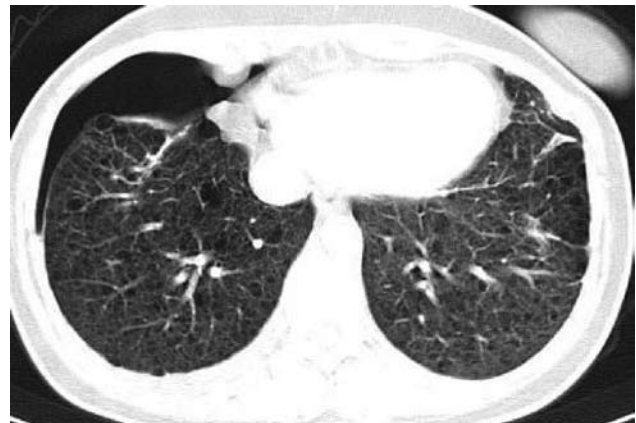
CT scan of the lung demonstrated small pleural effusion and pneumothorax of the right lung.
